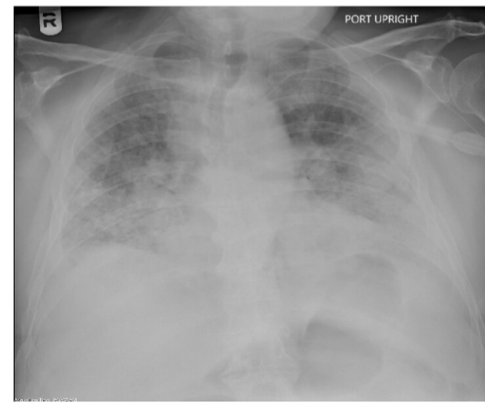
Chest X-ray on Day 14 showing diffuse lung whiteout concerning for ARDS.
